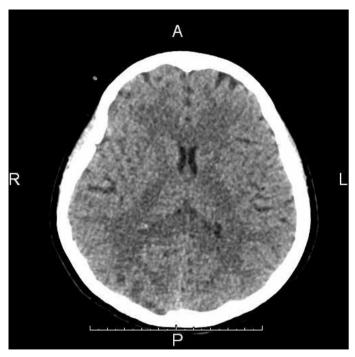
CT scan brain showing the parieto-occipital white matter edema
